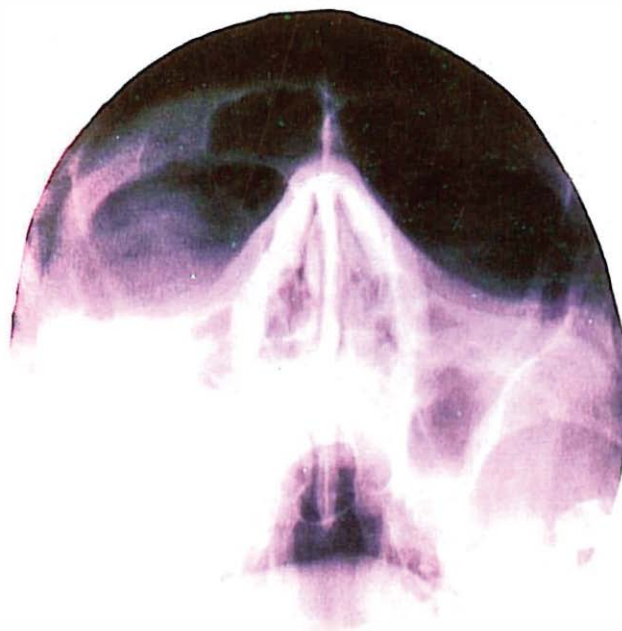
X-ray shows opacity of right maxillary sinus and hypertrophy of left sinus mucosa.
